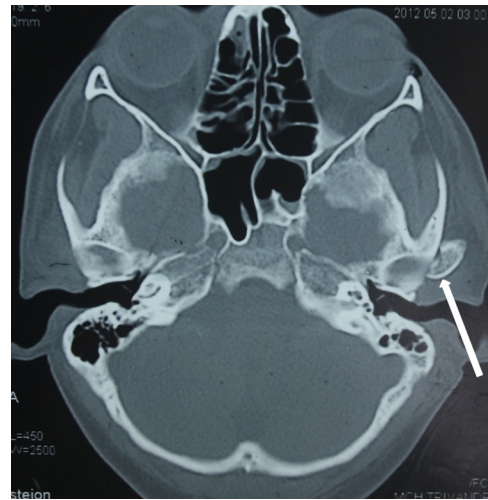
Another axial cut post trauma CT showing the lateral segment of sagittal fracture left condyle abutting the zygomatic arch.
